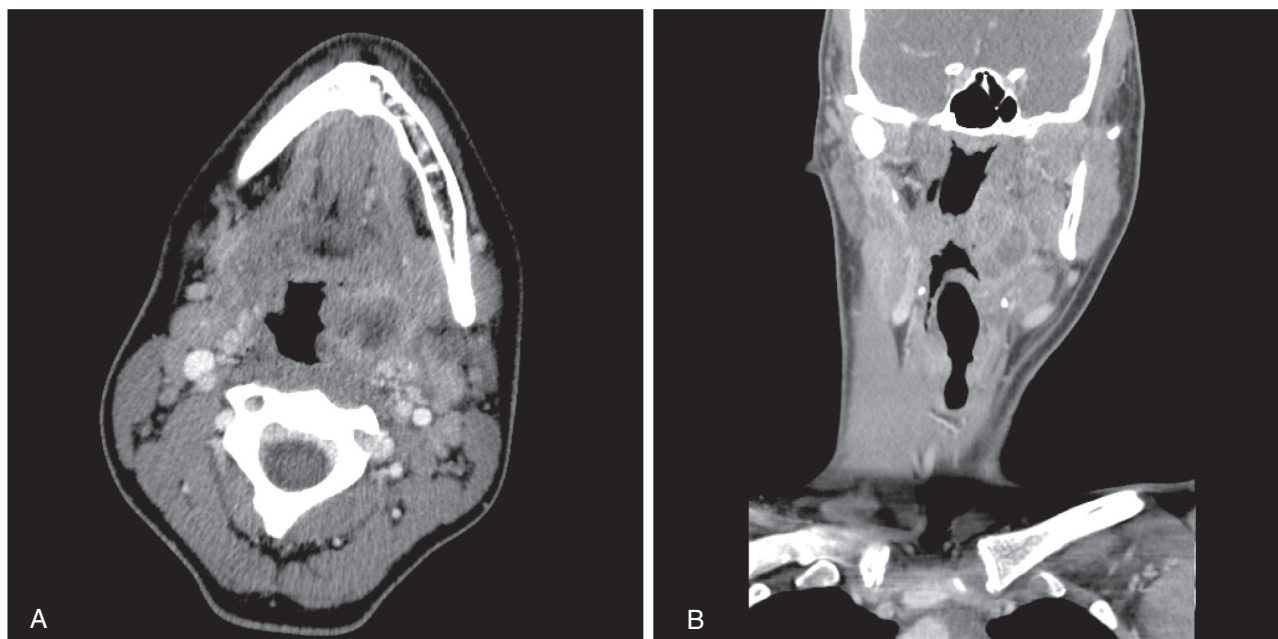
Contrast-enhanced axial (A) and coronal (B) CT image of a left-sided peripherally enhancing and centrally hypoattenuating peritonsillar abscess. There is mild mass effect on the oropharyngeal airway and mild inflammation of the fat in the left parapharyngeal space.
